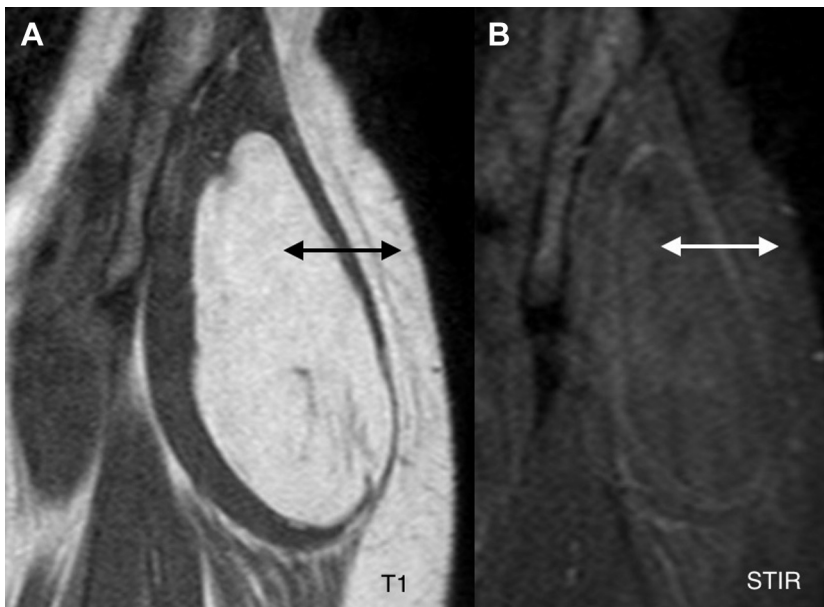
Intramuscular lipoma. Thigh MRI with T1 (A) and fluid-sensitive short tau inversion recovery (STIR) sequences (B), both demonstrating identical appearance of tumor tissue to nearby subcutaneous fat (double headed arrows).
